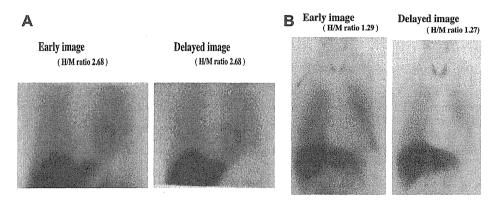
Cardiac Meta-iodobenzylguanidine (MIBG) scintigram of Kii patients with amyotrophic lateral sclerosis/parkinsonism–dementia complex (ALS/PDC). (1A) Patient # 1 showed ALS symptoms without parkinsonism or dementia; the uptake of ¹²³I-MIBG was normal. (1B) In patient # 6 who showed moderate parkinsonism, dementia, and ALS symptoms; there was almost no uptake of 123I-MIBG.
